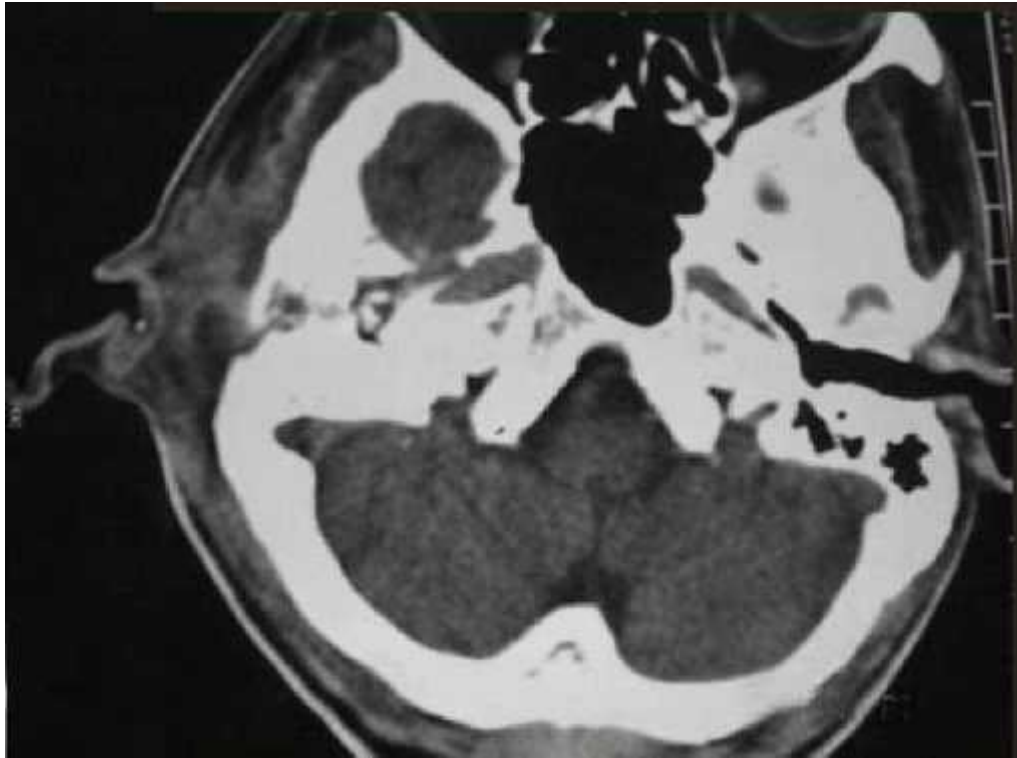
HRCT Axial brain window shows enhancing soft tissue density mass involving the right external auditory canal.
